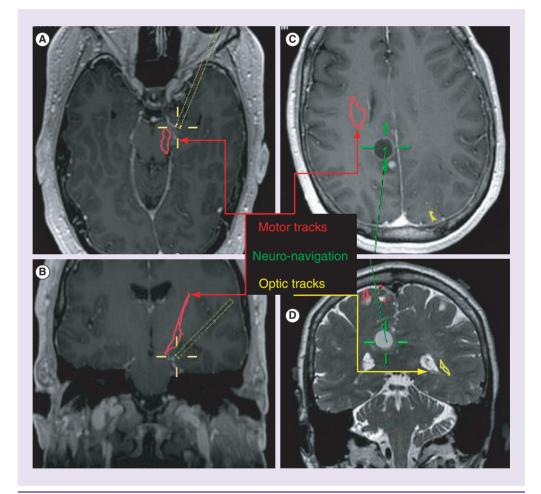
Intraoperative screenshot, demonstrating diffusion tensor imaging tracks. (A) Axial and (B) coronal post-gadolinium T1 enhanced MRI from a 36-year-old man with a lesion in the left amygdala. Motor (red) diffusion tensor imaging (DTI) tracks are shown at the level of the midbrain (A) and corona radiata and internal capsule (B). (C) Axial post-gadolinium enhanced and (D) coronal T2 MRI showing a 66-year-old woman with a cystic glioblastoma and enhancing mural nodule in the right posterior cingulate gyrus. Optic radiations (yellow) and corticospinal tracts (red) were generated using DTI imaging and are shown as well as neuro-navigation (green). For color images please see www.futuremedicine.com/doi/full/10.2217/cns.14.36
